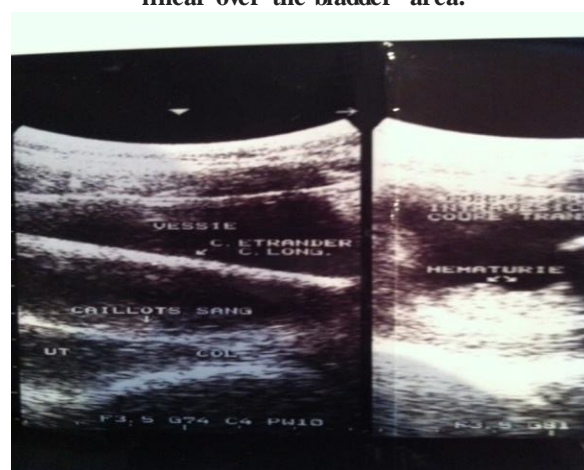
Ultrasound showing an intravesical linear hyperechoic picture.
